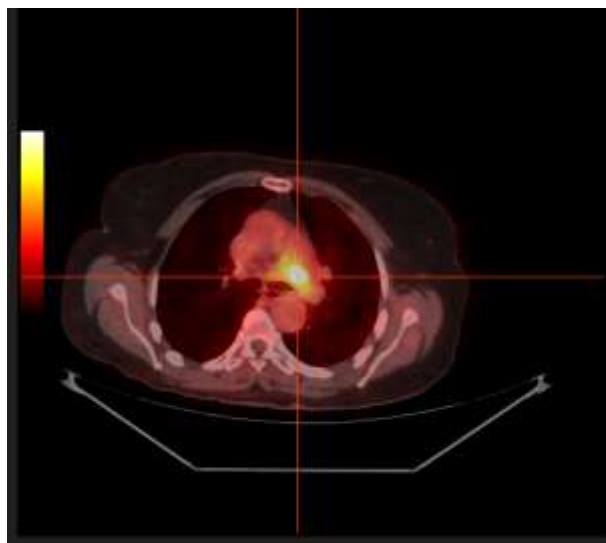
axial section of the PET scan with 18 F_FDG showing hypermetabolism of the lymph node focus in the aorto-pulmonary window
